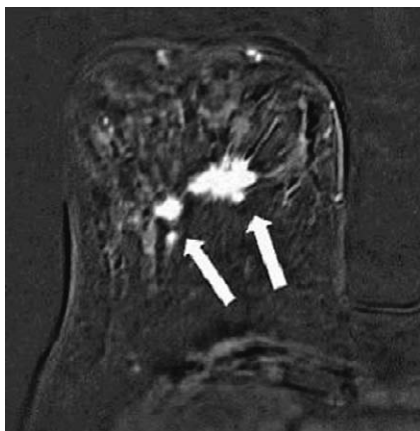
MRI of the right breast showing more than two enhancing mass lesions in a unique quadrant in a distance of  $\leq 5$  cm (arrow) (multifocal cancer).
